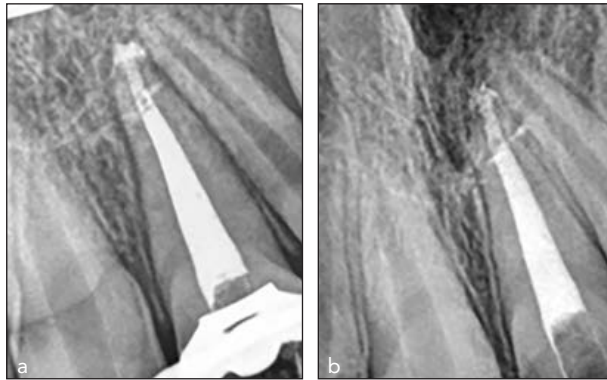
MTA apexification performed on a 10-year-old boy. (a) Immediate postoperative radiograph with evidence of periodontal ligament (PDL) widening. (b) Two-year follow-up radiograph with evidence of normal PDL structures and the absence of apical pathology.
